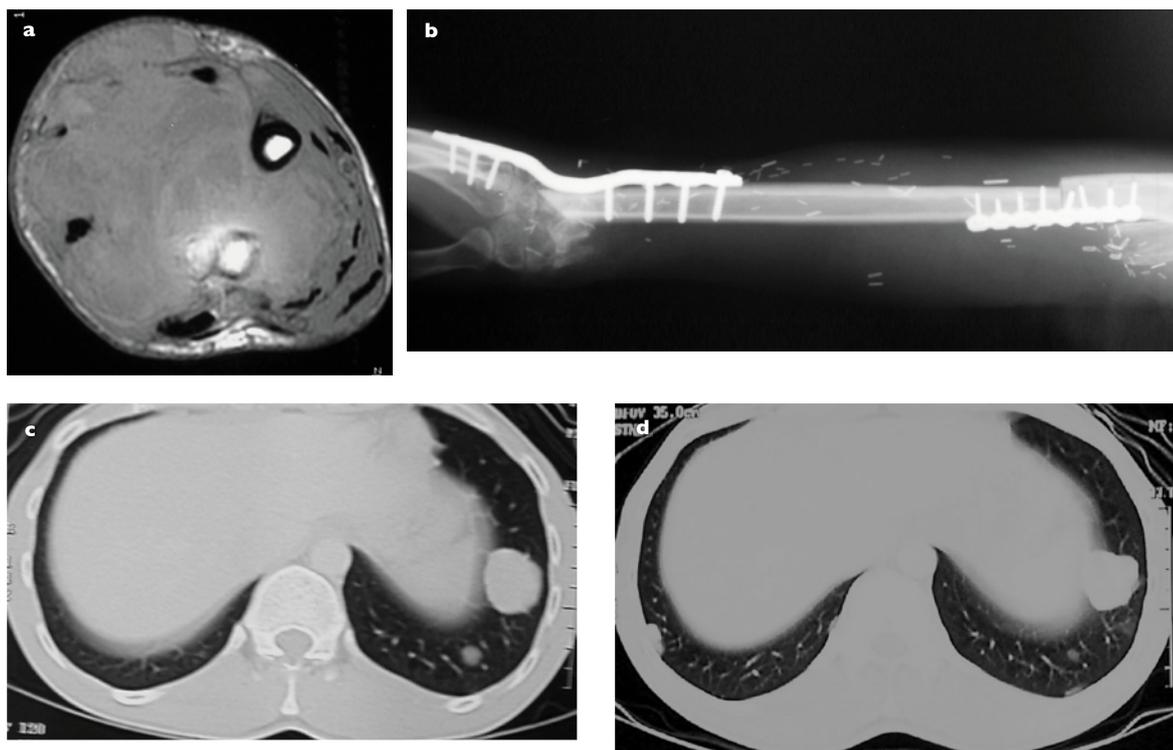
Case no. 12. A 28-year-old man presented with recurrent tumour of the distal radius, which was resected and reconstructed with vascularised fibular graft. He also had multiple pulmonary metastases that precluded surgical resection. He received six courses of adriamycin and cisplatin for six months. At present, he is asymptomatic and pulmonary nodules remain static. (a) Axial T1-W MR image shows distal radius giant cell tumour with massive soft tissue involvement. (b) Postoperative radiograph shows the vascularised fibular graft and wrist fusion. (c) at presentation shows multiple pulmonary metastases, and (d) after three years, shows no progression of pulmonary nodules.
